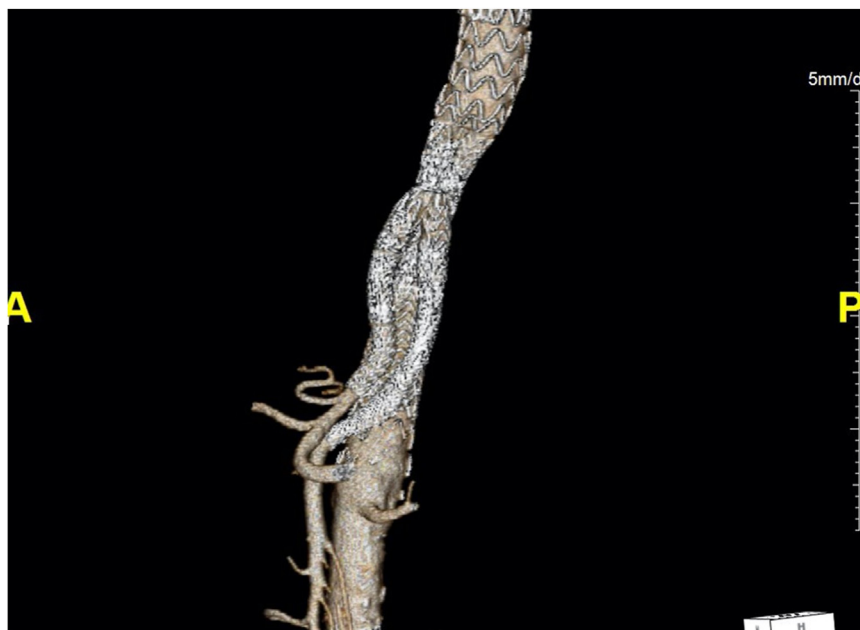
Postoperative three-dimensional reconstruction images from the patient's 1-month postoperative computed tomography angiogram.
